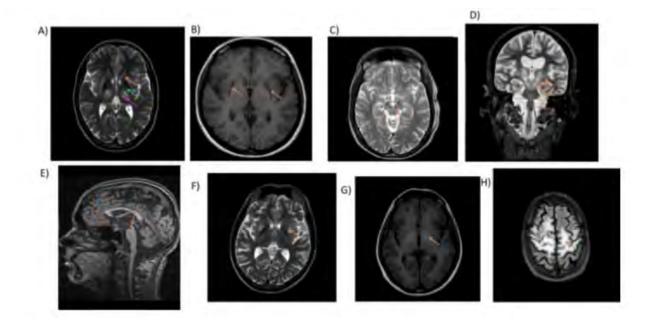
Adopted from (Członkowska et al., 2018) variations of Brain MRI in WD.
